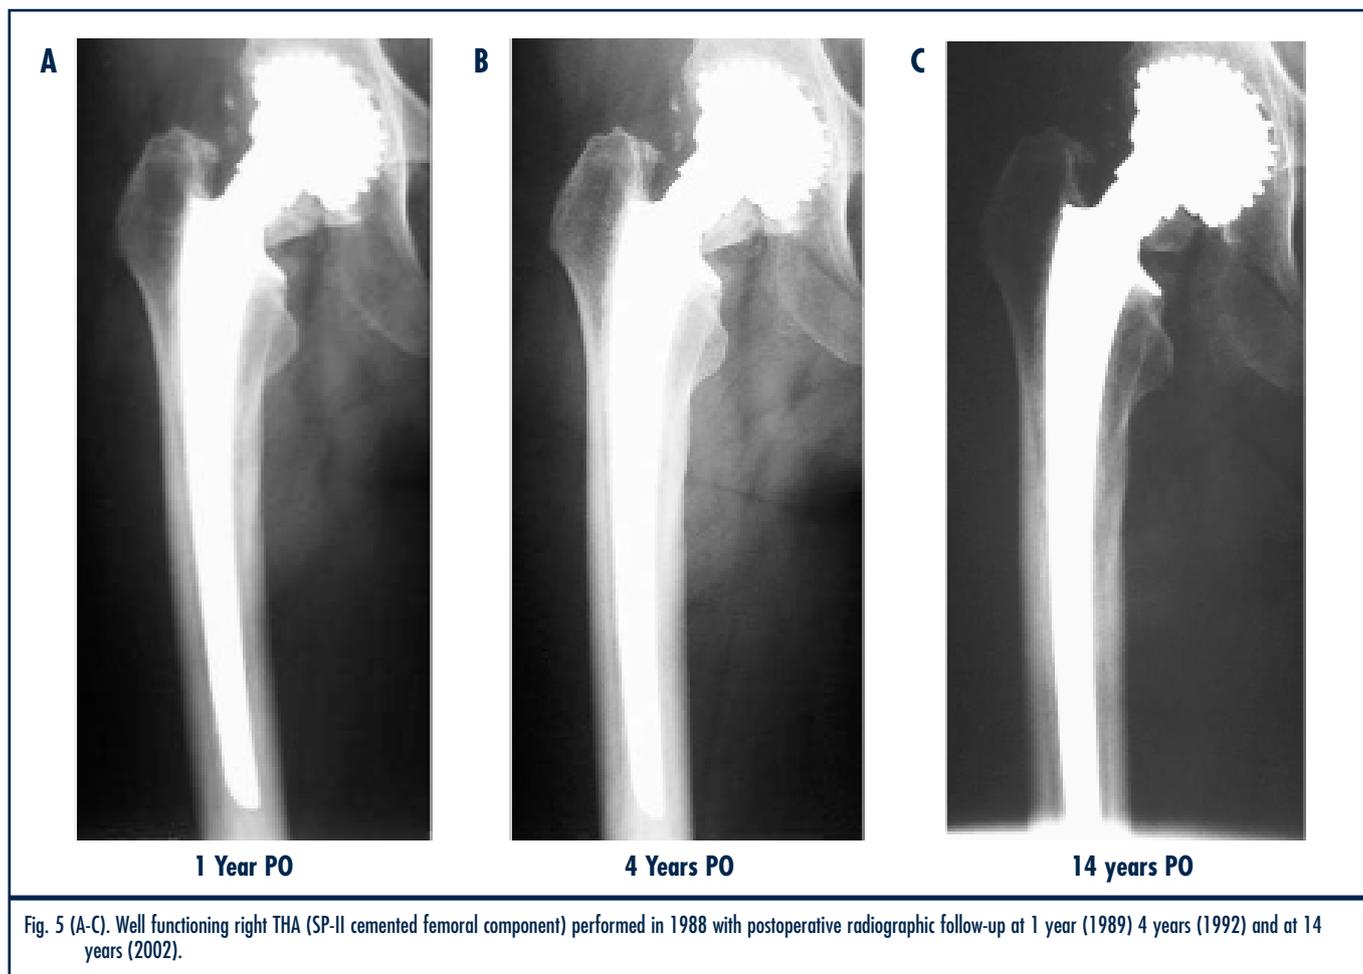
(A-C). Well functioning right THA (SP-II cemented femoral component) performed in 1988 with postoperative radiographic follow-up at 1 year (1989) 4 years (1992) and at 14 years (2002).
